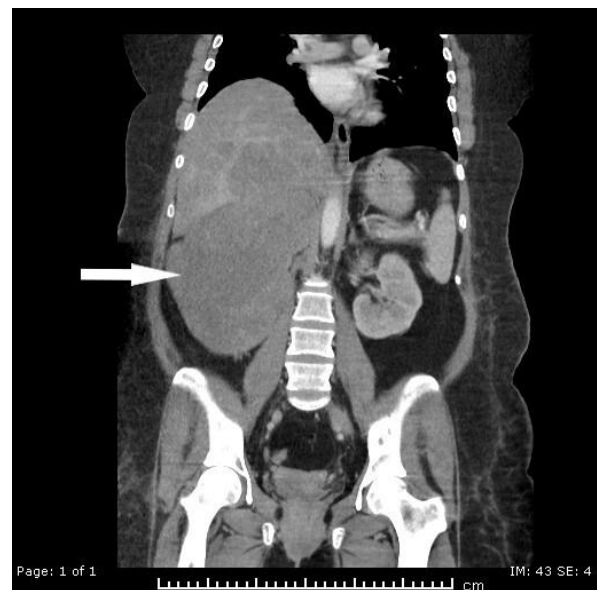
Contrast-enhanced CT image, coronal and sagittal section: A lobulated contoured hypodense mass filling the right adrenal lodge and extending inferiorly. The mass has a component on the superior part that erases the liver contours and invades the liver. It is seen that the mass depresses the right kidney downwards.
